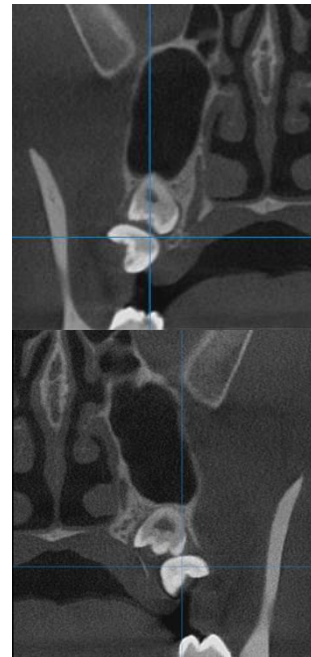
CBCT cross sectional view quadrant 1 and 2
